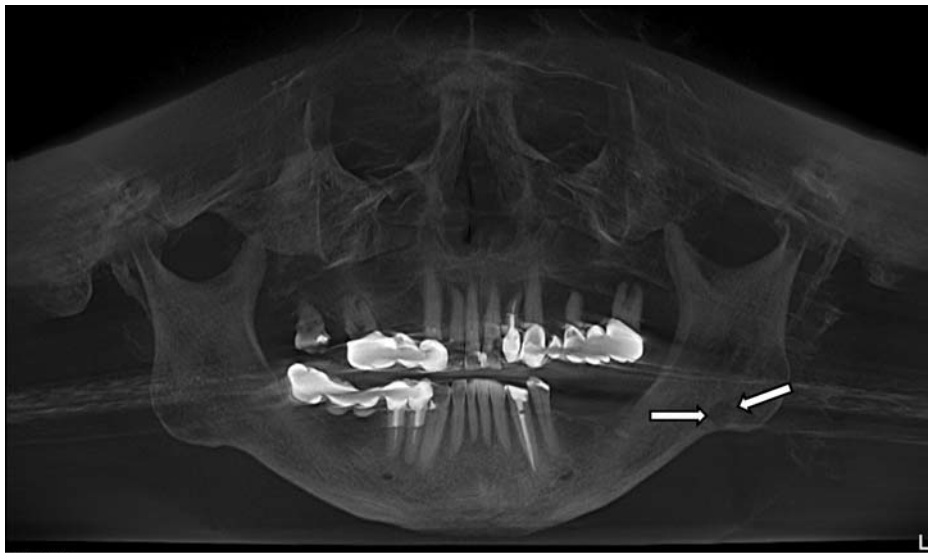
Cone beam computed tomography of a 73-year-old male patient with Stafne's bone cavity in the left mandibular angle, with a round form.
